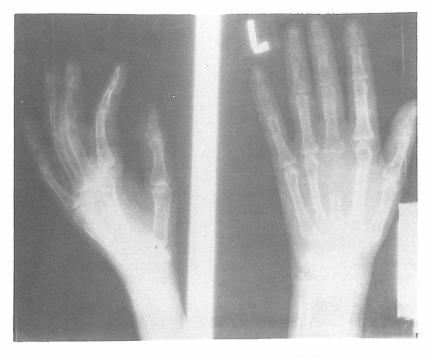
X-ray of the hands, demonstrating loss of lamina dura.
